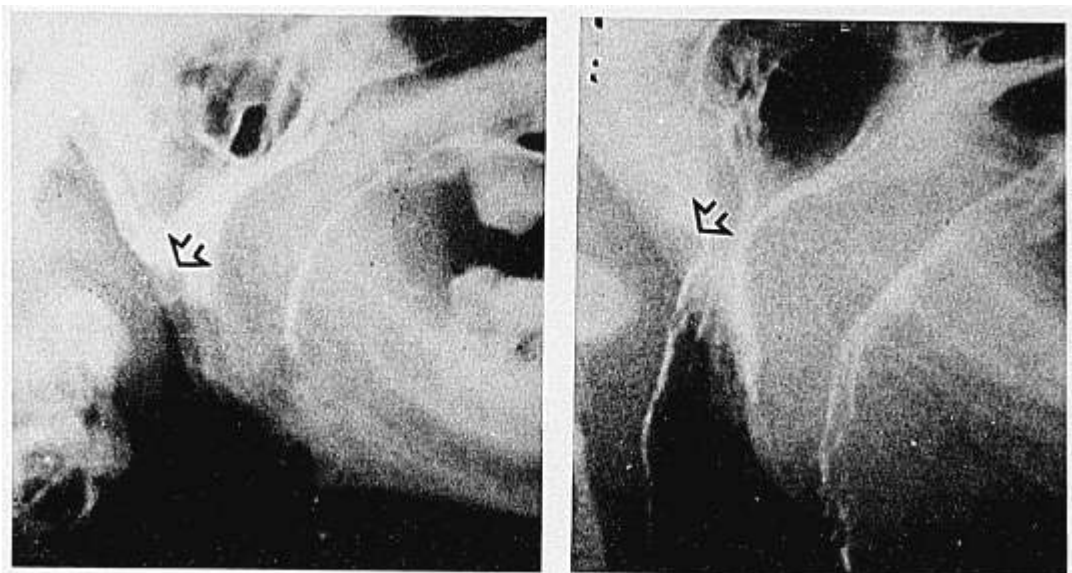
Lateral radiographic view of the velopharyngeal valve during FST. Note the typical forward bulging of the velum forcefully attached to the raised base of the tongue. Passavant's ridge on the posterior pharyngeal wall is indicated by the arrows.
